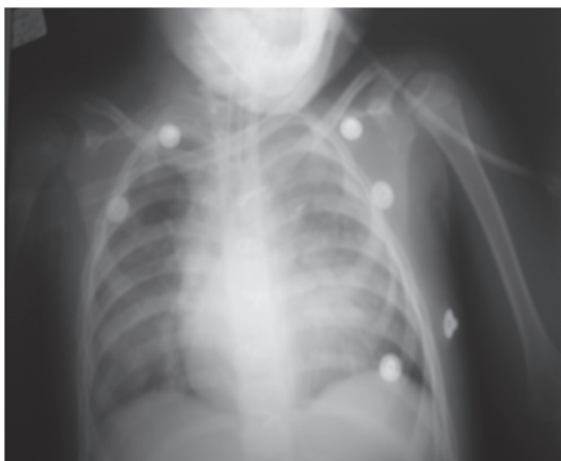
Chest X-ray taken after the patient's massive pulmonary hemorrhage.
